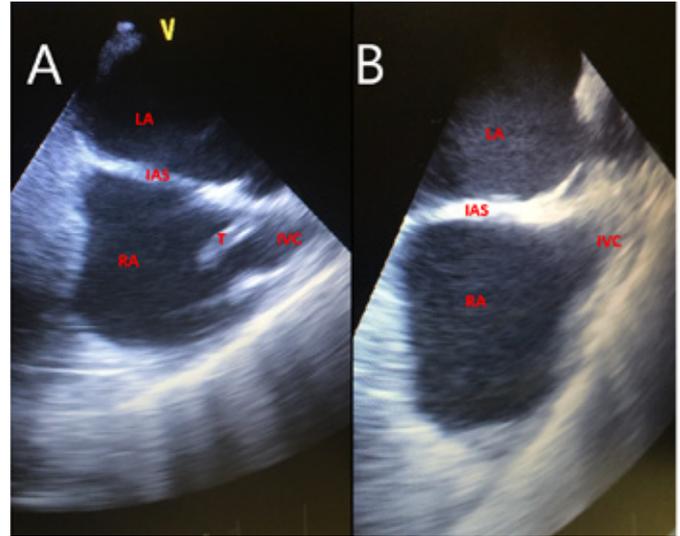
Transesophageal echocardiography (TEE) demonstrating the IVC thrombus before (A) and after (B) AngioVac therapy. RA; right atrium, LA; left atrium, IAS; interatrial septum, IVC; inferior vena cava, T; thrombus
